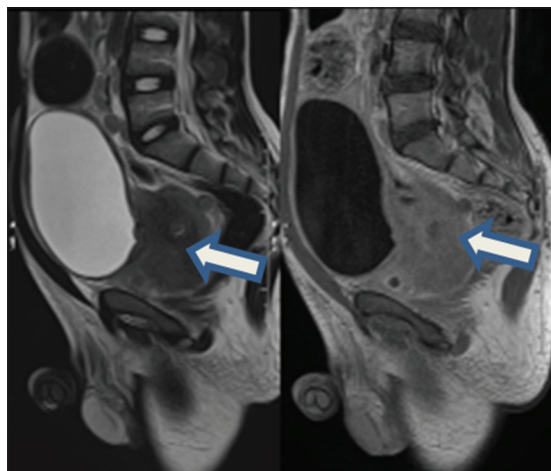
A sagittal T1WI and T2W2 MRI image of the prostate: The prostate is almost entirely replaced by the tumor mass. The mass is indenting the bladder base. The central necrotic area is noted (white arrow).
